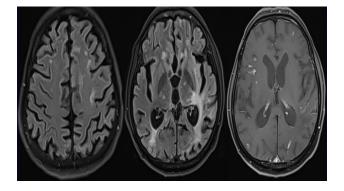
PLHA presented with altered sensorium with a CD4 count was 67 cells. Asymmetric confluent areas of T2/FLAIR hyperintensity in bilateral periventricular white matter deep and subcortical white matter in bilateral fronto-occipital region (left>right), left insular and left temporal lobe. Punctate foci of enhenacement noted in bilateral cerebral hemispheres.
